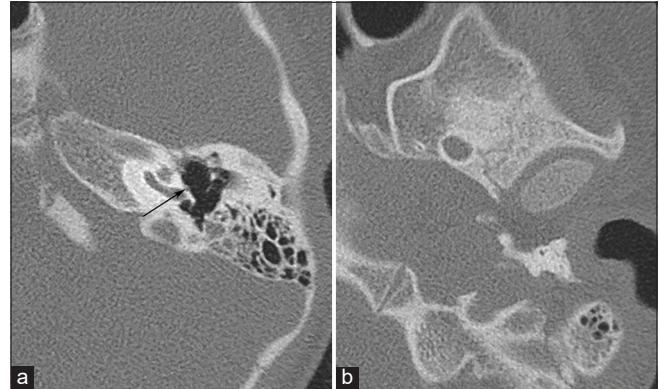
A 27-year-old woman with persistent stapedial artery. (a) Axial high-resolution computed tomography images at the level of middle ear and (b) floor of the middle cranial fossa. There is a tiny soft-tissue focus along the cochlear promontory (arrow). This was seen to course along the horizontal segment of the facial nerve on sequential images (not shown). Image at level of skull base (b) reveals absent foramen spinosum.
